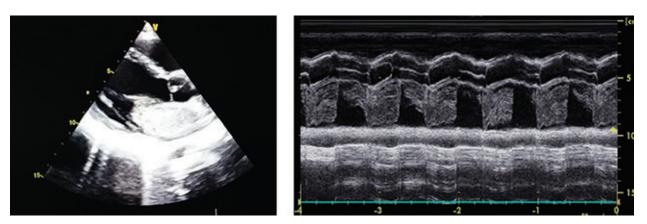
2D and M mode echocardiography showing large myxoma occupying most of the LA.
